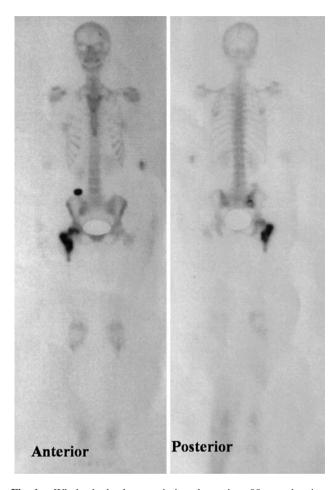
Whole body bone scintigraphy using 99m technetium methylene diphosphonate demonstrated increased radiotracer uptake in the proximal right femur, as well as in the right sacroiliac joint and skull
